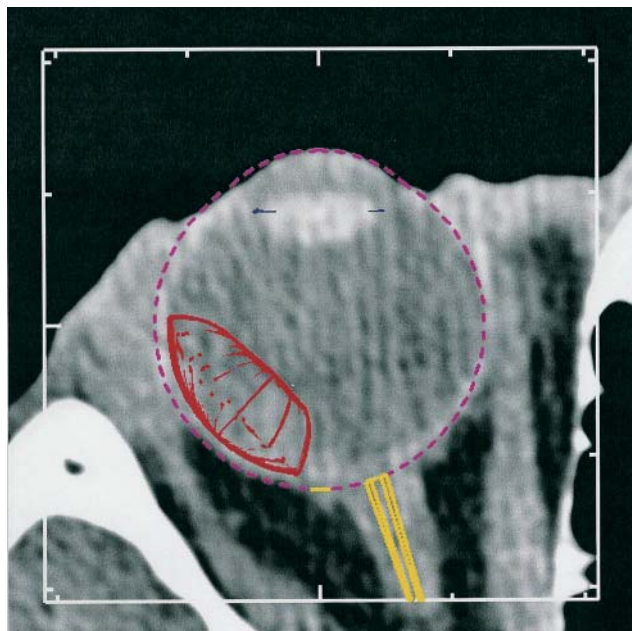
Export of the EYEPLAN contours into the planning CT for stereotactic radiotherapy with photons.
